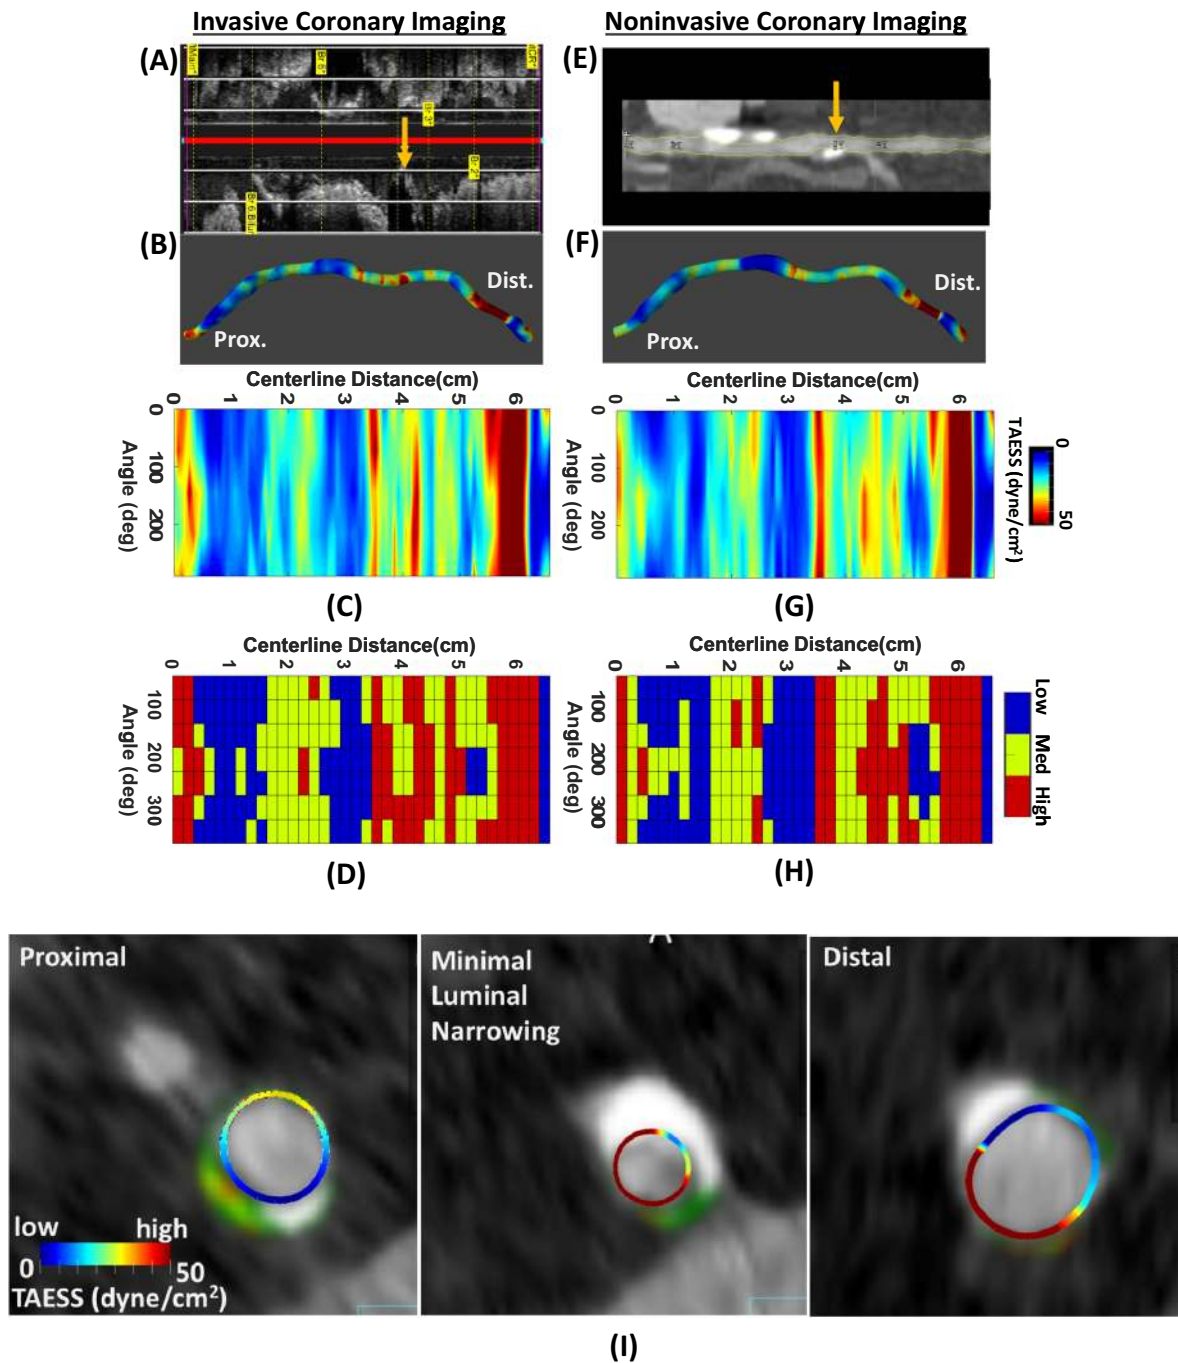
A representative comparison of TAESS calculating based on invasive IVUS and coronary CTA imaging. Long-axis view of left anterior descending (LAD) based on IVUS and CTA with location of plaque marked with yellow arrows (a, e). 3D anatomy reconstruction with TAESS mapped on the LAD (b, f). The “unrolled” 360° values of continuous TAESS (c, g) and categorical low, medium and high
